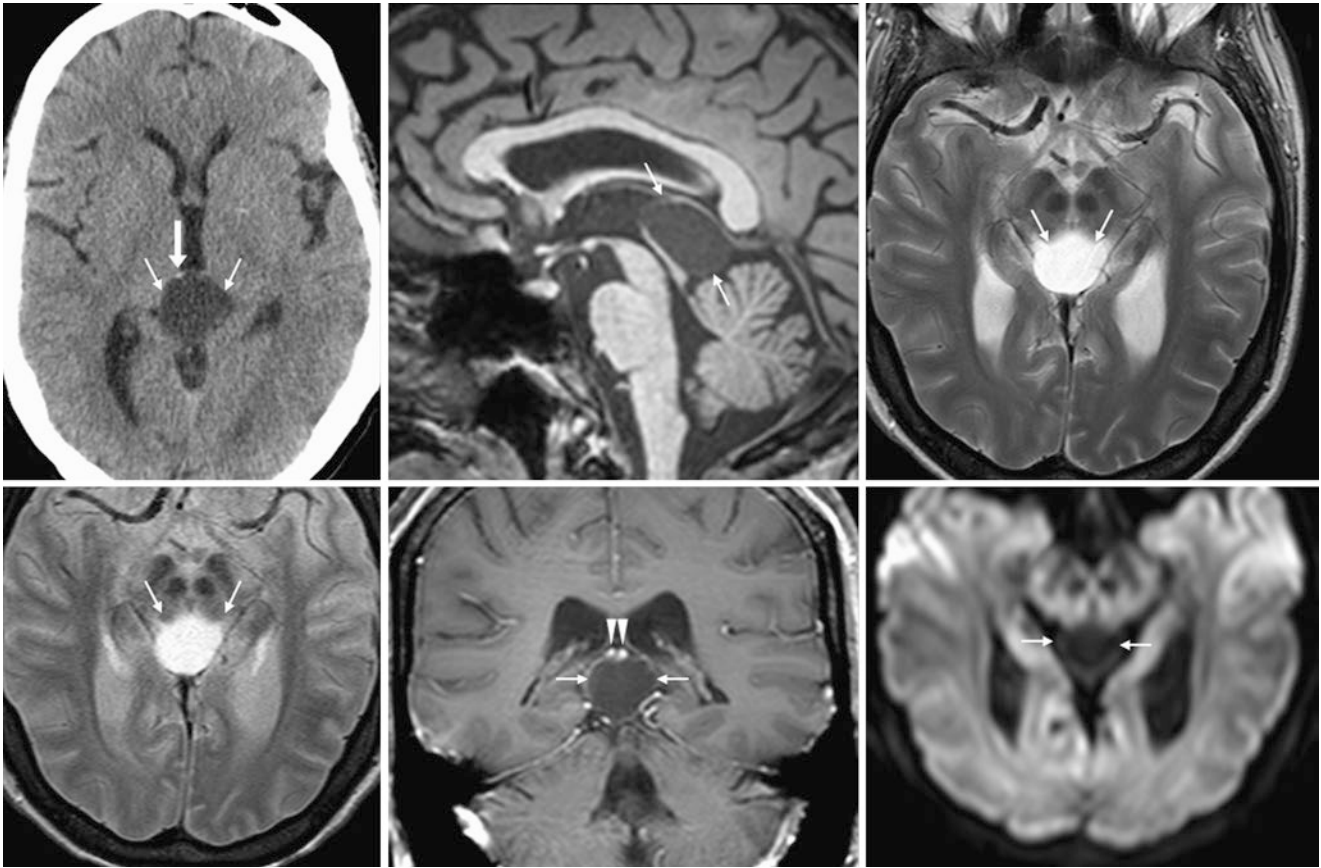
Companion case of pineal cyst with mass effect. In a 36-year-old, a NECT (*top left*) 1 month post-trauma (no initial images obtained) found a 2.5-cm pineal cyst (*thin arrows*) that displaced calcifications peripherally (*larger arrow*). 3 T sagittal T1WI (*top middle*) showed that the cyst compressed the tectum but without hydrocephalus. The cyst was bright on T2WI (*top right*) and FLAIR (*bottom left*). It had
